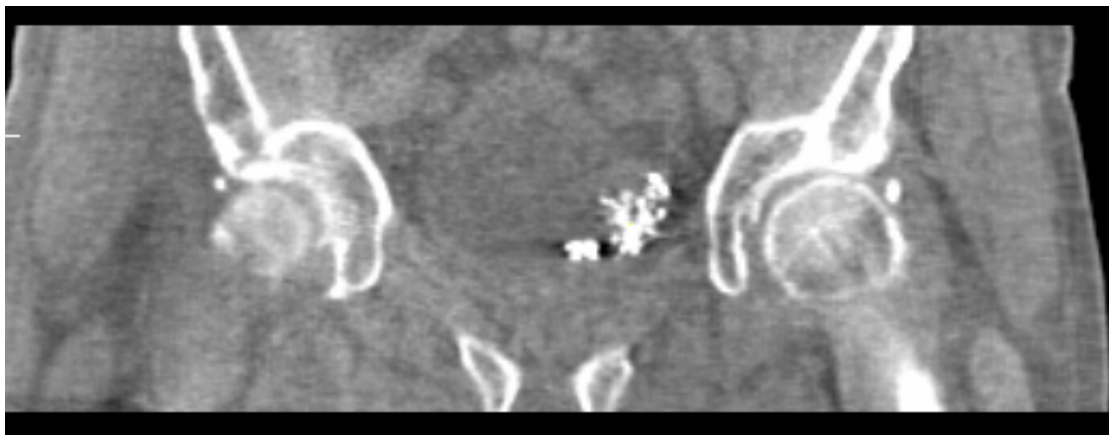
Coronal view of a CBCT image using created preset Bladder C.
